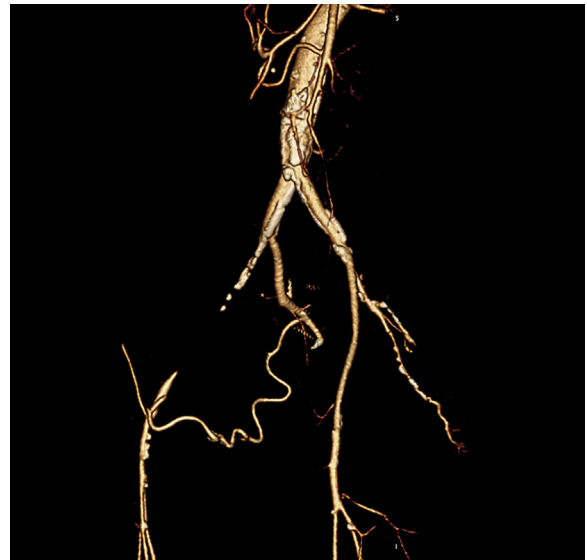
Three-dimensional reconstruction of CT angiography (left anterior oblique view) showing the site of thrombosis in the right external iliac artery. Calcified aortic bifurcation and common iliac arteries are shown. Residual perfusion of the right femoral artery results from a branch of the internal iliac artery.
